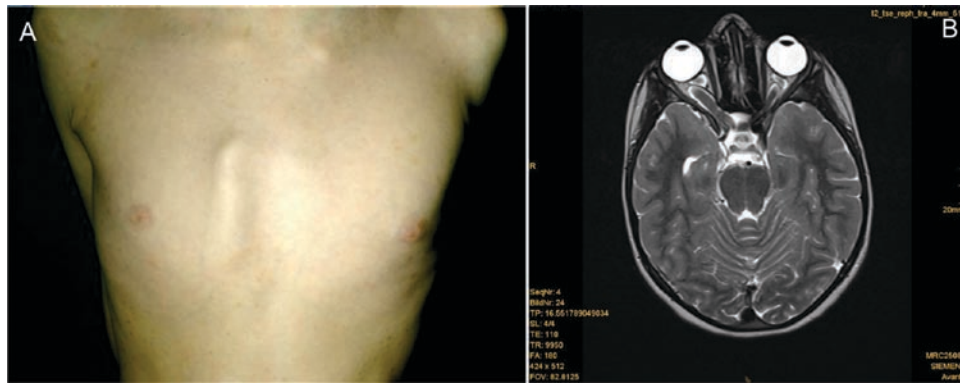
Clinical findings of neurofibromatosis type 1. (A) Chest deformity, freckling of the axillary regions and café-au-lait macule. (B) Bilateral optic gliomas were more pronounced on the right eye in magnetic resonance imaging (MRI).
